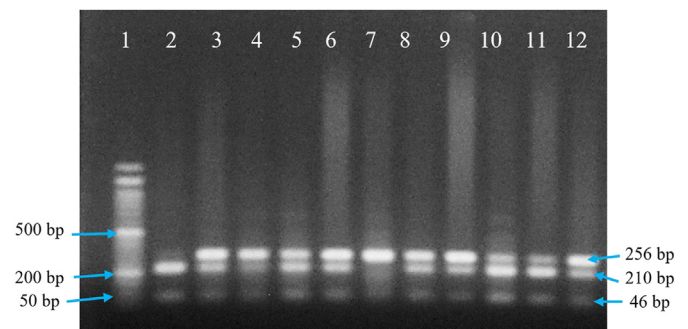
Restriction Endonuclease (*MspI*) digestion fragments of rs13266634 allele of *SLC30A8* gene (1% agarose gel). Lane-1: 50 bp molecular ruler; Lanes-3-6 and 8-12: heterozygous (CT) form (46, 210 and 256 bp); Lane- 7: mutant (TT) form (256 bp); lane- 2: wild-type (CC) form (46 and 210 bp).
